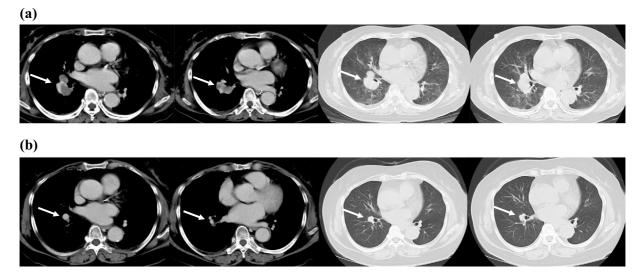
Enhanced computed tomography of the chest. A tumor was detected in the right pulmonary hilum before (a, arrowhead) and after (b, arrowhead) four courses of chemotherapy using carboplatin and etoposide.
